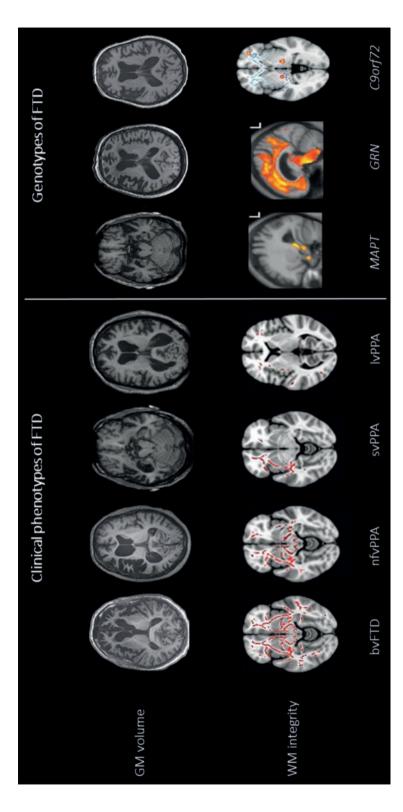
Pattern of GM volume and white matter integrity loss in the clinical phenotypes and genotypes of FTD. Top row represents the grey matter volume loss per clinical phenotype (bvFTD, nfvPPA, svPPA, vPPA) and genotypes of FTD (MAPT, GRN, C9orf72) on T1-weighted MRI scans (in the transversal plane – upper part of the INPPA) and genotypes of FTD (MAPT, GRN, C90rf72) on diffusion tensor weighted MRI scans (in the transversal plane - plane - upper part of the image is the front of the brain, lower part is the back of the brain or sagittal plane; images for MAPT and GRN are in sagittal plane – the left side is the front of the brain, the right side is the back of the brain. The red/blue lines and orange blobs represent the fractional anisotropy (FA) loss (one of the four measures for white matter integrity). Abbreviations: FTD, frontotemporal dementia; GM, grey matter; WM, white matter; bvFTD, behavioural variant frontotemporal dementia; nfvPPA, non-fluent variant primary progressive image is the front of the brain, lower part is the back of the brain). Bottom row represents the white matter integrity loss per clinical phenotype (bvFTD, nfvPPA, svPPA, aphasia; svPPA, semantic variant primary progressive aphasia; IvPPA, logopenic variant primary progressive aphasia; MAPT, microtubule-associated protein tau; GRN, progranulin, C90rf72, Chromosome 9 open reading frame 72; L, left.
